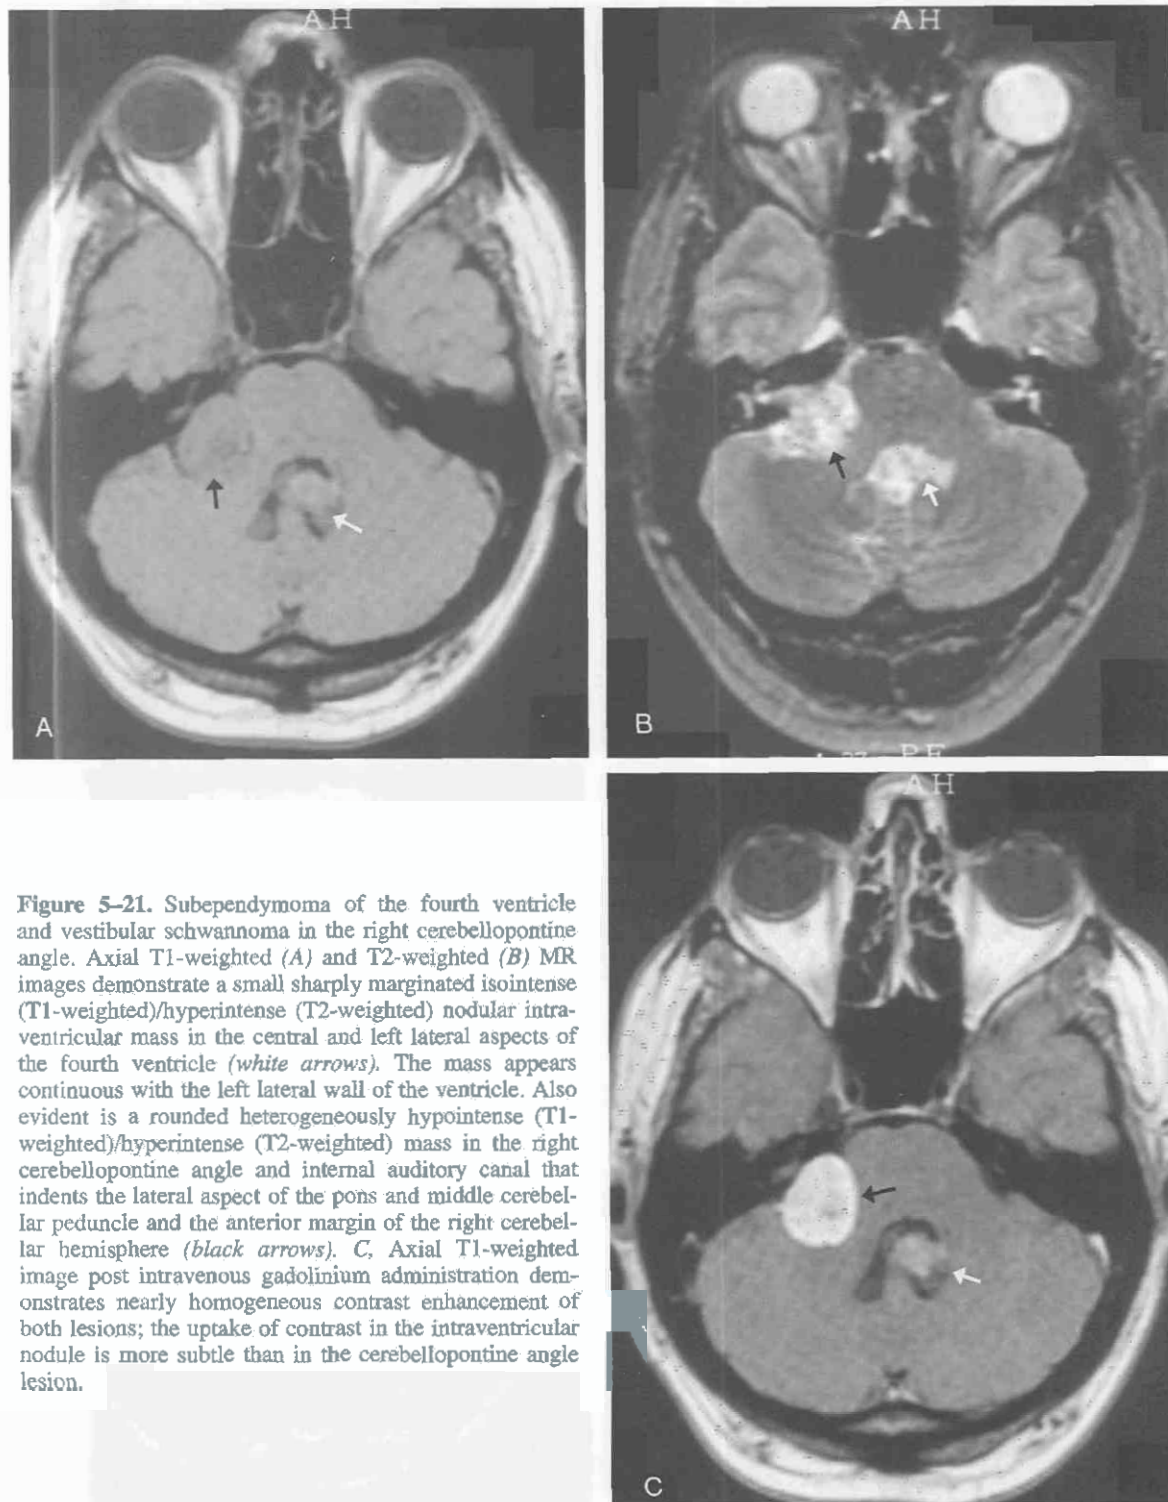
Subependymoma of the fourth ventricle and vestibular schwannoma in the right cerebellopontine angle. Axial T1-weighted (A) and T2-weighted (B) MR images demonstrate a small sharply marginated isointense (T1-weighted)/hyperintense (T2-weighted) nodular intraventricular mass in the central and left lateral aspects of the fourth ventricle (white arrows). The mass appears continuous with the left lateral wall of the ventricle. Also evident is a rounded heterogeneously hypointense (T1-weighted)/hyperintense (T2-weighted) mass in the right cerebellopontine angle and internal auditory canal that indents the lateral aspect of the pons and middle cerebellar peduncle and the anterior margin of the right cerebellar hemisphere (black arrows). C, Axial T1-weighted image post intravenous gadolinium administration demonstrates nearly homogeneous contrast enhancement of both lesions; the uptake of contrast in the intraventricular nodule is more subtle than in the cerebellopontine angle lesion.
